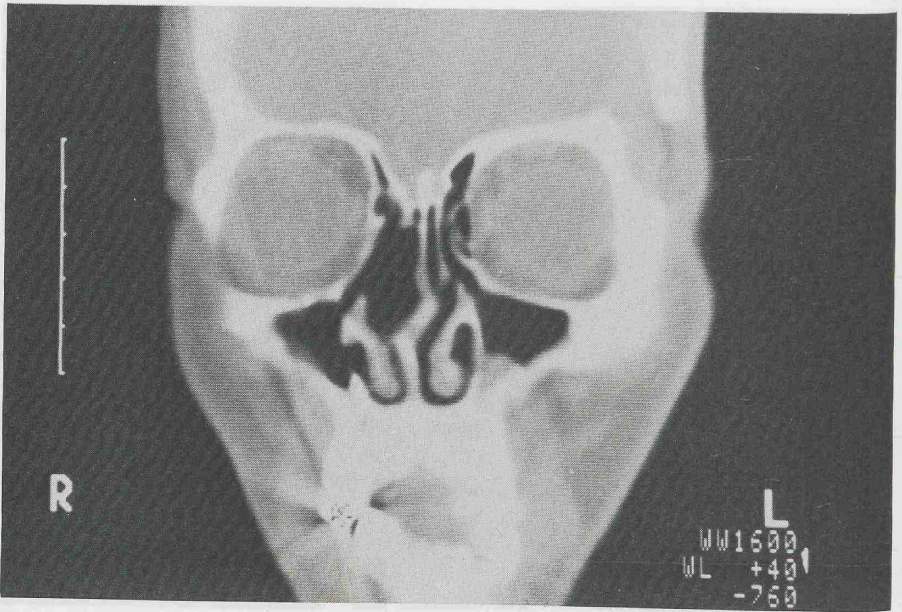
The CT-scan evaluation after one year. No tumour was evident.
